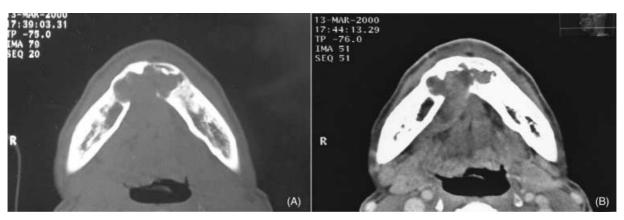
Computed tomography revealed a multilocular soft tissue density mass of the anterior mandible extending into the floor of mouth (A: bone level; and B: soft tissue level).
